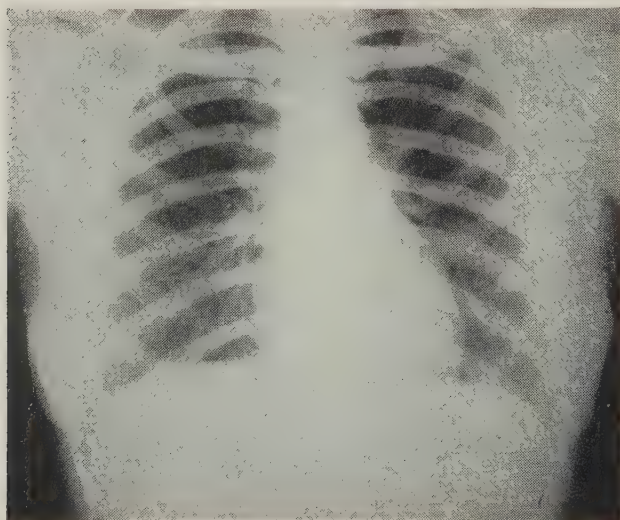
Complete resolution of the lobar pneumonia, left lower lobe, is demonstrated on this roentgenogram made on September 3, 1958, after ristocetin treatment. (Case E. D.)
